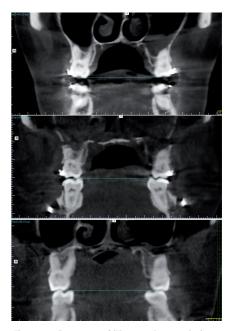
Patient 1. CT coronal views before surgery and 1 week and 1 year after surgery (top to bottom).
